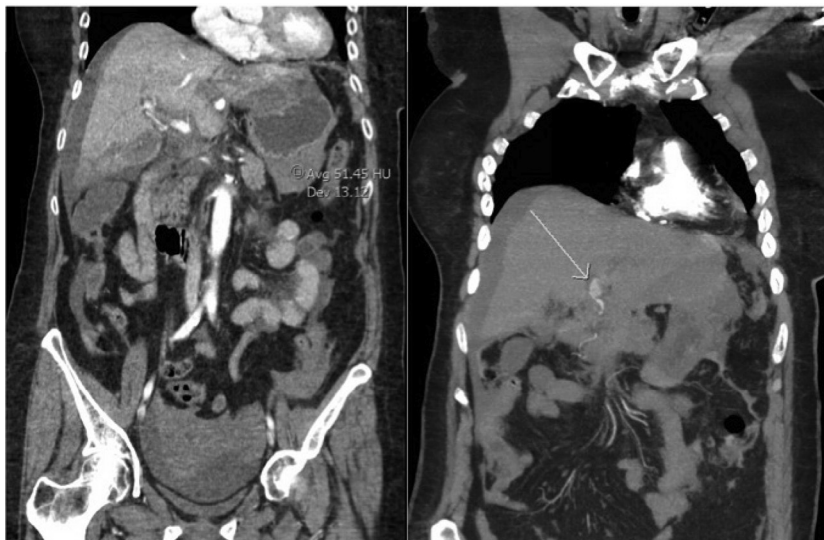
Computed tomography of the abdomen and pelvis with contrast showing hemoperitoneum and an aneurysm arising off the right hepatic artery.
